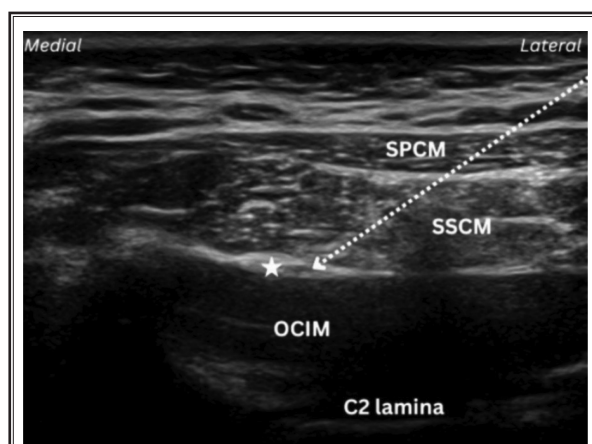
Ultrasound image of the greater occipital nerve (GON) at the C2 level.
